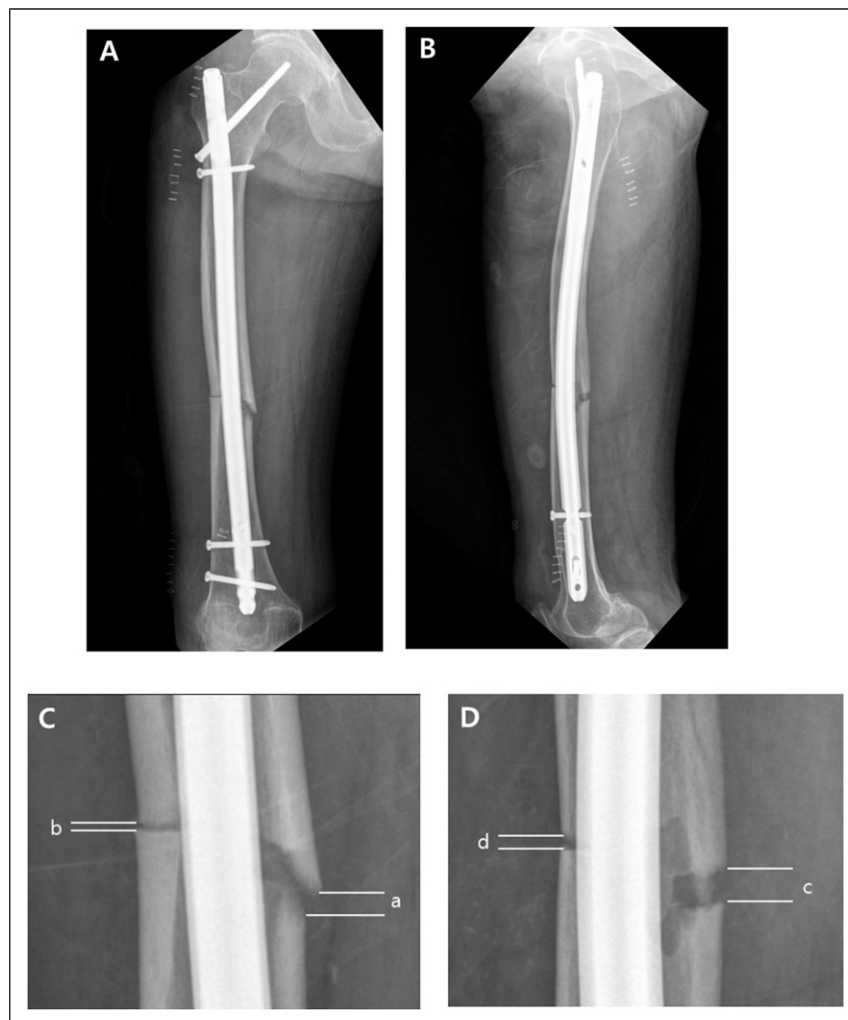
In atypical femoral fracture with anterolateral bowing, a medial and posterior opening wedge-shaped gap at the fracture site is confirmed after performing intramedullary nailing (A, B). In anteroposterior and lateral simple radiographs, medial (a), lateral (b), posterior (c) and anterior (d) gaps at the fracture site were measured (C, D). The ML gap ratio was defined as a/b , and PA gap ratio was defined as c/d .
